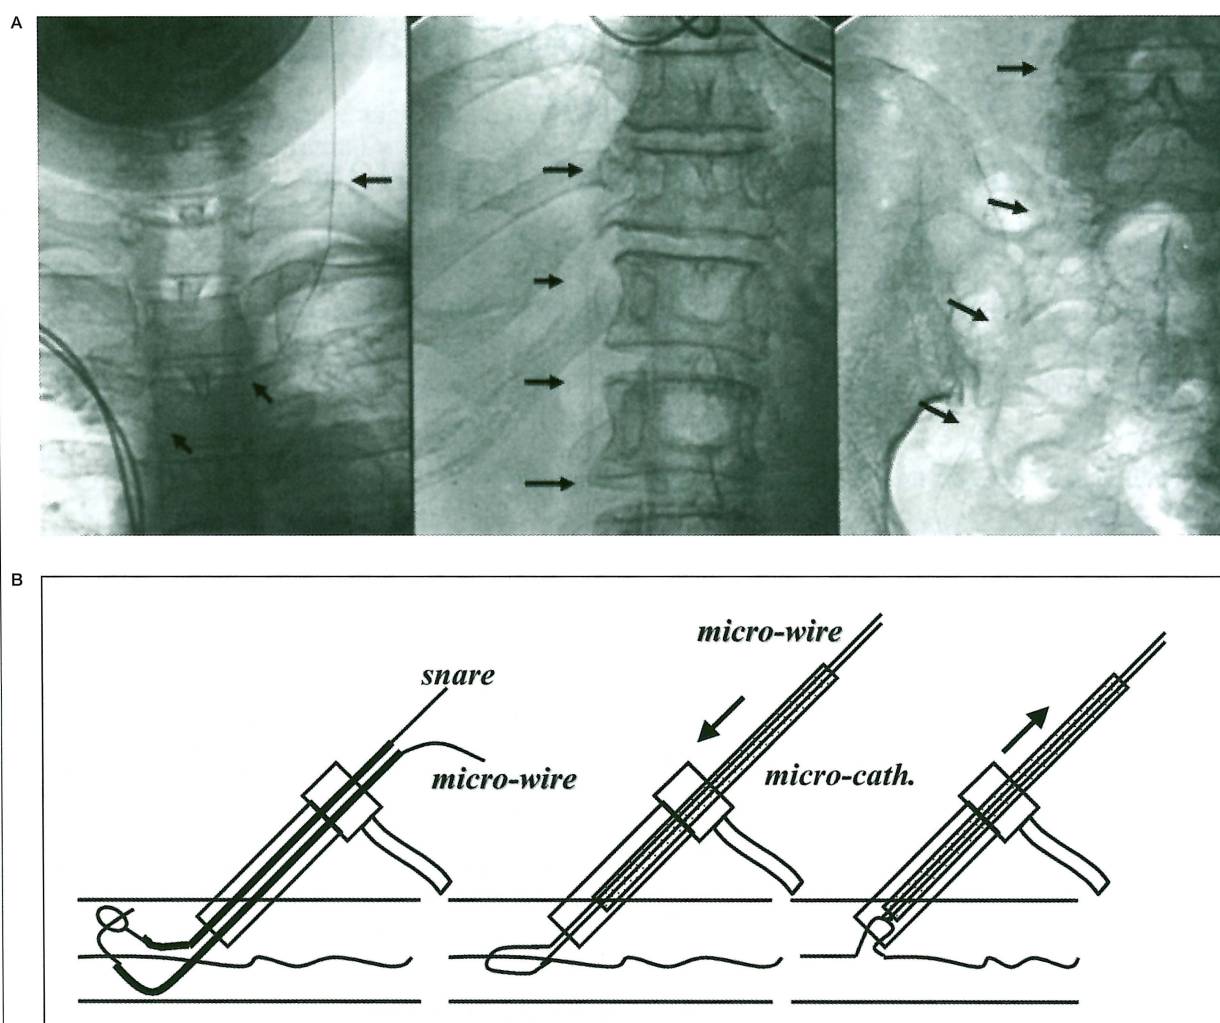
A) Plain neck, chest, and abdominal radiograph. The broken coil remained stretched from the cavernous sinus to the right femoral vein. B) Our method of retrieval of the stretched mechanically detachable coil from the internal jugular vein.
